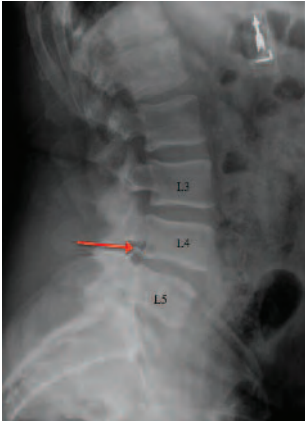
Lateral spinal x-ray taken during the patient's first visit. Imaging shows minimal displacement at L4/5 (red arrow), but overall looks benign.
